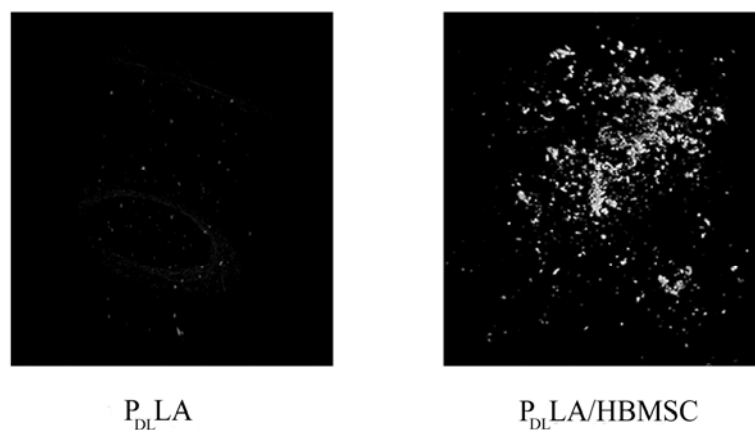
Micro CT images of new bone formation. Representative 3D images of new bone formation in impacted P_{DL}LA / HBMSC and P_{DL}LA alone samples.
